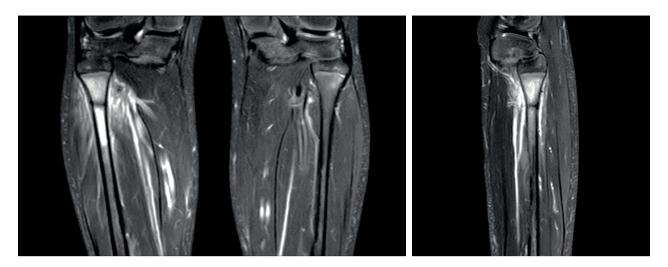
MRI images with soft tissues and marrow edema associated with a fracture line through the cortex of the proximal fibula.
